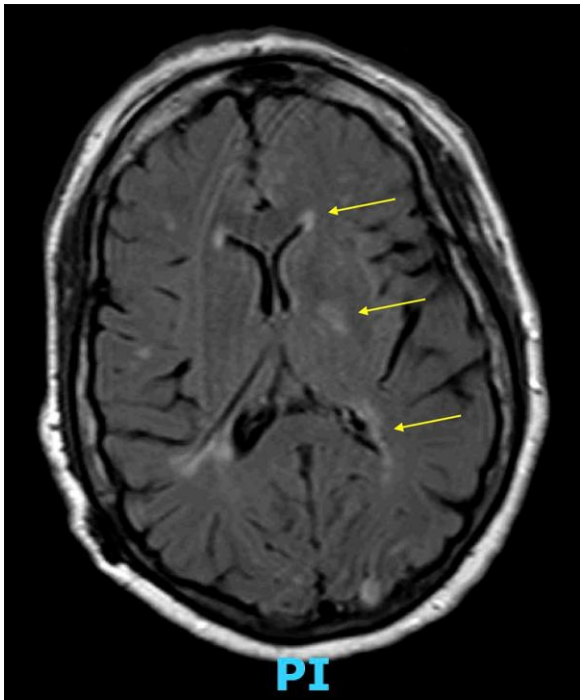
Brain magnetic resonance imaging with evidence of left supratentorial subacute ischaemic stroke (arrows).
